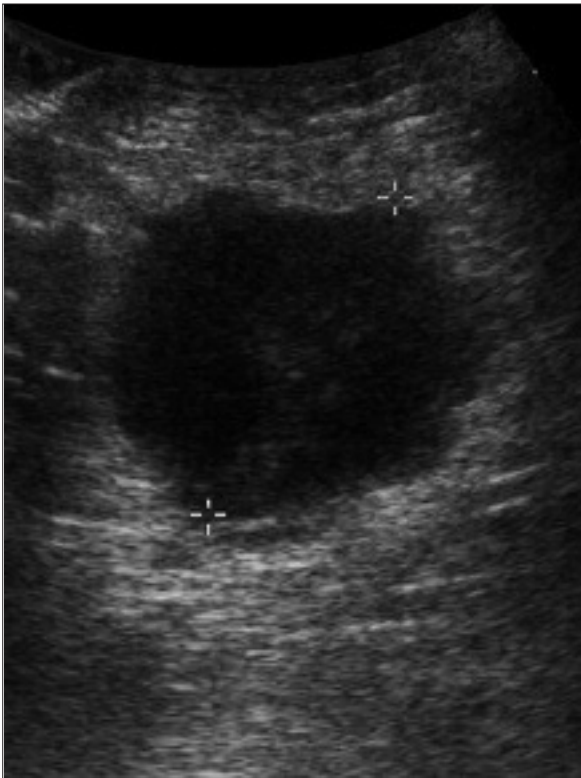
Ultrasound of the left axilla (patient 1): circumscribed fluid accumulation with a diameter of circa 4, 3 cm (special thanks to Dr. F. Seifert, Vöcklabruck).
